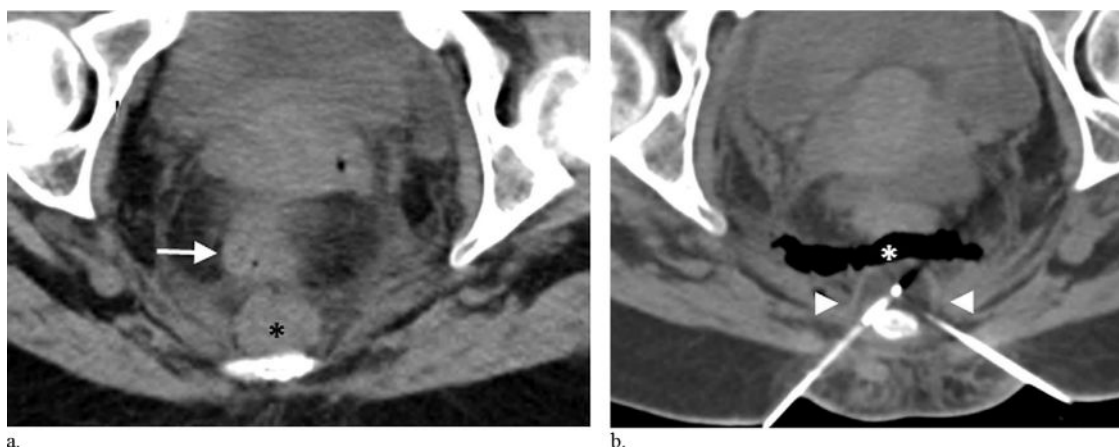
A 45-year-old woman with metastatic non-small cell lung cancer and severe low back pain requiring hospital admission for pain control. On physical examination, her pain was localized to the coccyx. Axial CT image (a) shows a soft tissue mass immediately anterior to the coccyx (black asterisk), in close proximity to the rectosigmoid colon (arrow). Axial CT image (b) after a 22-gauge needle has been used to inject carbon dioxide (white asterisk) into the fat plane between the mass and the colon, separating the 2 structures. Two cryoprobes have been placed on either side of the coccyx and an ice ball has formed that envelops the tumor (arrowheads). The patient reported nearly complete pain relief immediately after the procedure.
